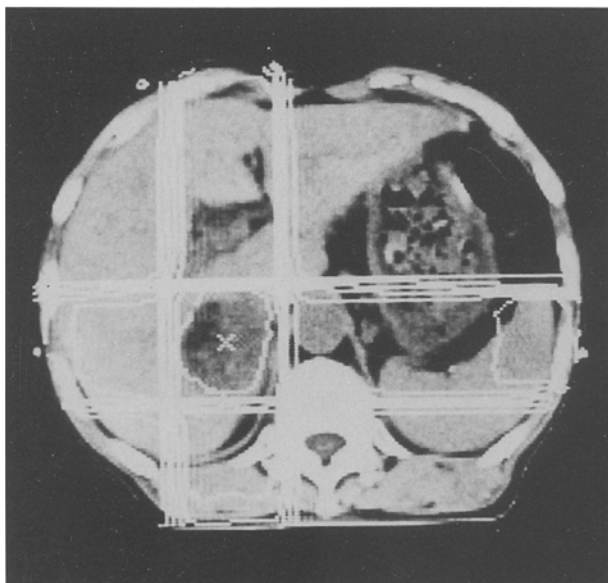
Dose distribution in case 2 as drawn on a CT image using a Therac 2300 planning computer
